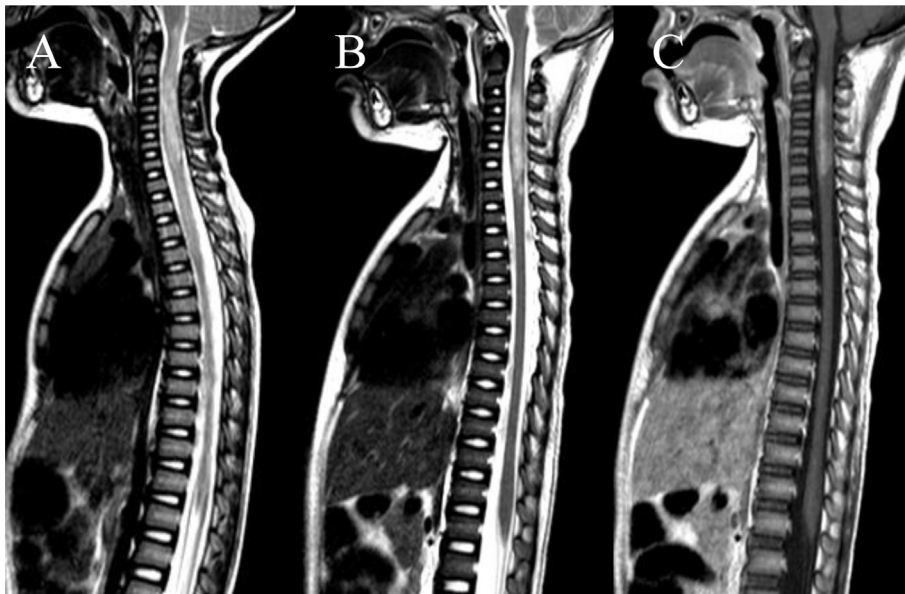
Magnetic resonance imaging. (A) T2-weighted images revealed a symmetric area of high signal intensity involving the lower end of the medulla oblongata to the level of the fourth thoracic vertebra 3 days after onset. At 10 days after symptom onset, T1-weighted images showed (B) a reduction in the size of the lesion but (C) partial enhancement effects.
